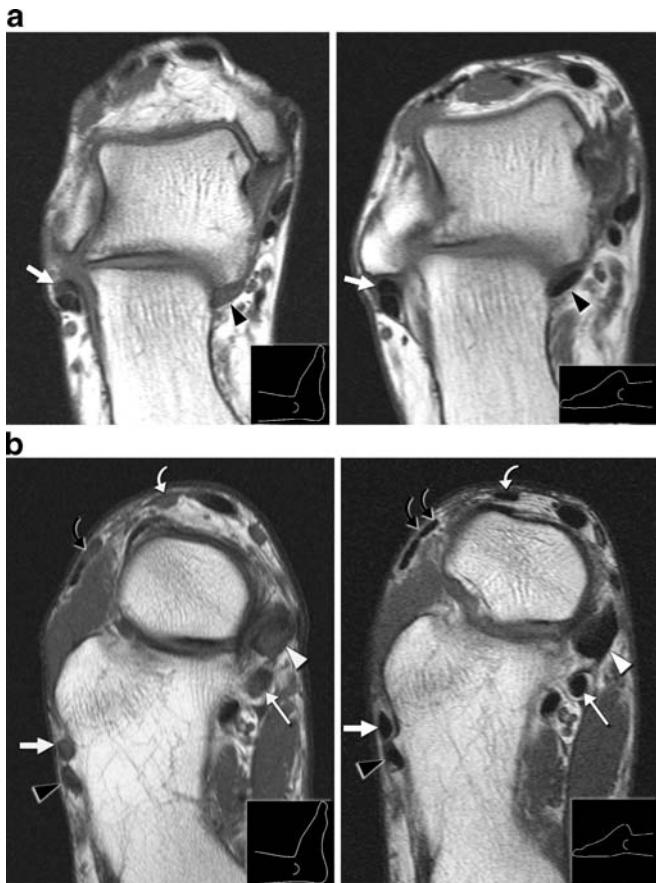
Magic angle effect in MRI of ankle tendons in asymptomatic subjects. Transverse oblique T1-weighted images (435/14) in supine body position with neutral position of the foot (left) and in prone body position with plantar flexion of the foot (right). a Imaging plane at the inferior tip of medial malleolus (51-year-old asymptomatic woman). In supine body position (left), the PB tendon (white arrow) and the FHL tendon (black arrowhead) show diffusely increased signal due to MAE. After repositioning with plantar flexion of the foot (right) a normal dark signal is seen within the PB and FHL tendons. At this level no MAE is seen within the ATT, PTT, FDL and PL tendons. b Imaging plane just anterior to the sustentaculum tali at the level of the trochlear process of the calcaneus (37-year-old asymptomatic man). In the supine body position with neutral position of the foot (left), MAE with diffusely increased signal is visible within the PTT (white arrowhead), FDL (small white arrow), PB (white arrow), PL (black arrowhead), EHL (curved white arrow) and EDL tendon (second and third tendon) (curved black arrow). In this position only the ATT and the FHL tendon have no MAE. In the prone body position with plantar flexion of the foot (right), all ankle tendons show a normal dark signal with no MAE
